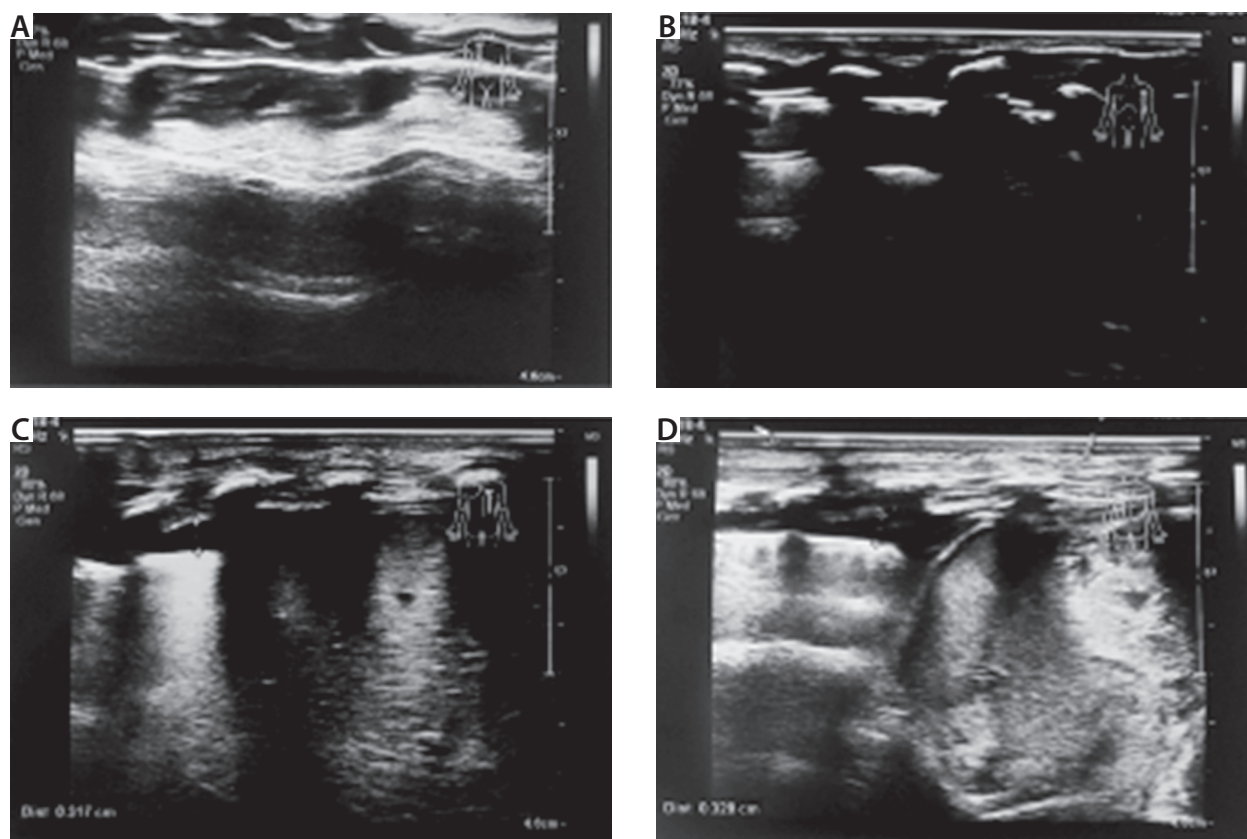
Lung ultrasound revealed the presence of fluid in the pleural cavities and air in the right pleural cavity on the first day of life. The following views are included: A) right anterior view, B) left anterior view, C) right posterior view, D) left posterior view
